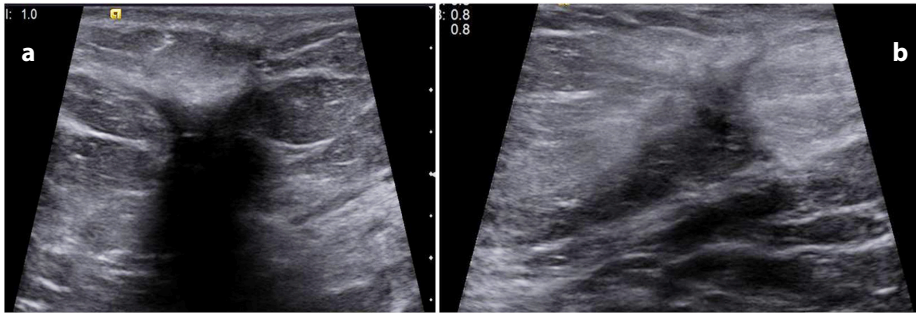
(a, b) US images of a 50-year-old patient treated with WBRT show a planar scar. The lesion is irregular with shadowing on one plane (a), but it is elongated on the orthogonal plane (b) and is easily diagnosed as a scar. US, ultrasound; WBRT, whole breast radiotherapy.
